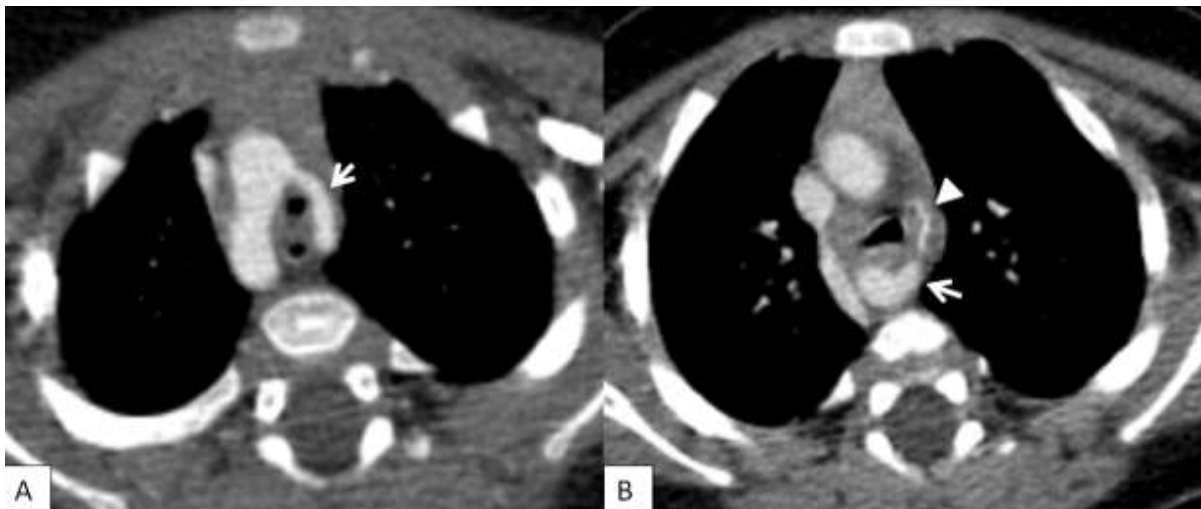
Angio Thoracic CT in axial section:
